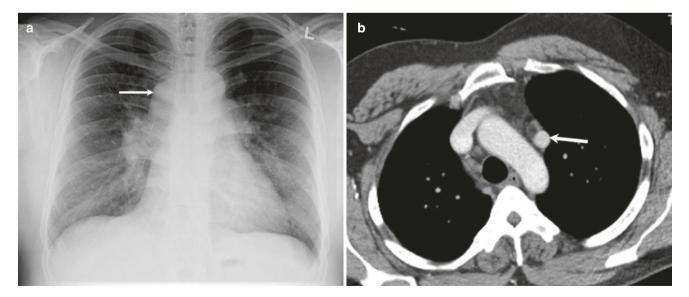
PAPVD in a 56-year-old woman with abnormal chest radiograph. (a) Frontal chest radiograph shows an opacity in the right trachea-bronchial angle (white arrow). (b–d) Axial CT images show that the right paratracheal opacity is due to dilated azygos vein (AV)
